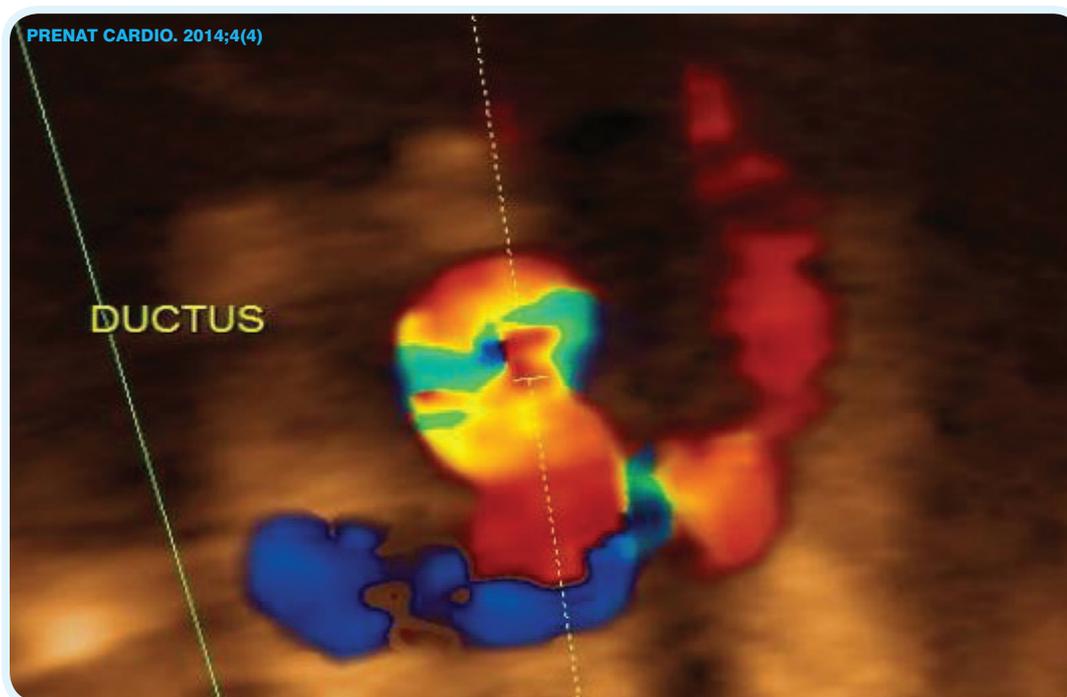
Ductal constriction. Color Doppler in a 33 weeks fetus exposed to a maternal polyphenol-rich diet. Notice the turbulent ductal flow.
